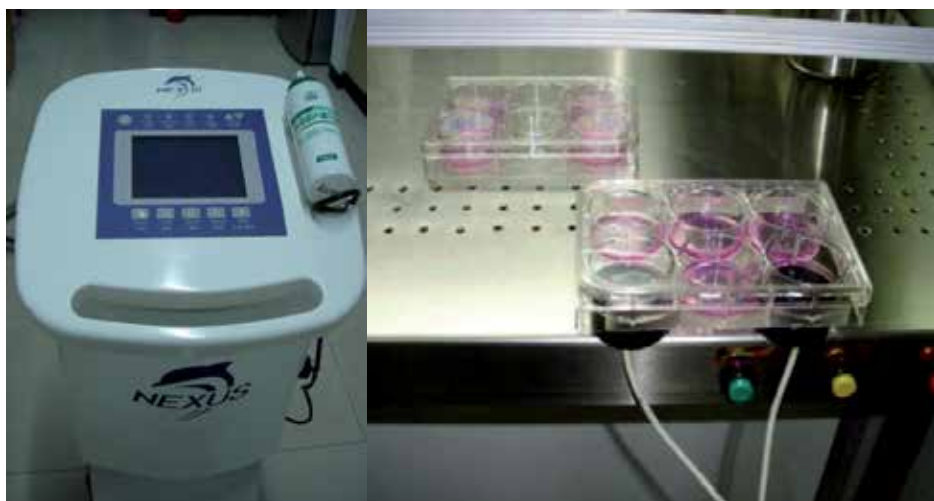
Experimental apparatus for applying low- intensity pulsed ultrasound (LIPUS) which generated LIPUS with a SATA intensity of  $10 \text{ mW/cm}^2$ , pulse width of 200 microseconds, repetition rate of 1.5 KHz, and an operation frequency of 1MHz. LIPUS irradiated neurons with two probes 24 h after in culture. A six-well plate was placed on the probes. LIPUS was transmitted to culture plate via an interposed ultrasound gel. Two transducers for the control group (sham-LIPUS; LIPUS not turned on) and two probes for the LIPUS group.
